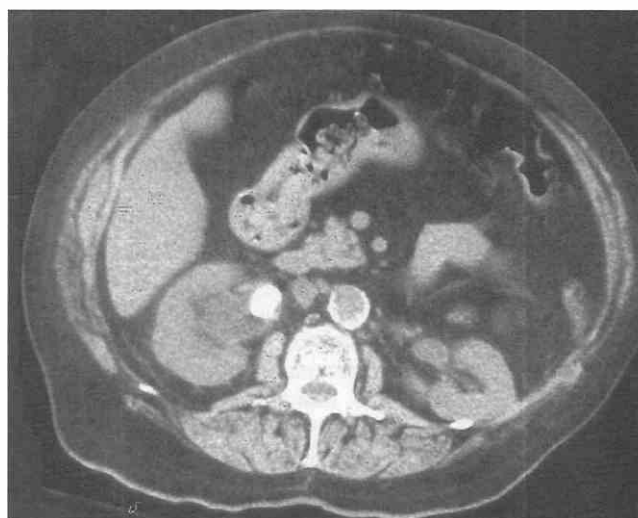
Axial CT scan demonstrates a large right ureteropelvic junction calculus.
